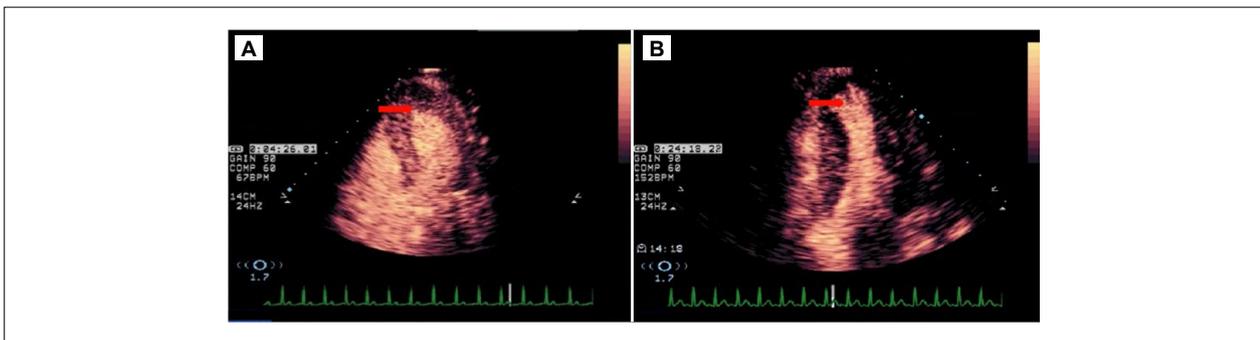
Sample contrast echocardiography under pharmacological stress with dobutamine and atropine. (A) Apical four-chamber plane at rest showing normal regional parietal motility and myocardial perfusion (red arrow). Video 5A. (B) Apical four-chamber plane at peak stress showing akinesia and a myocardial perfusion defect in the apical region (red arrow). Video 5B.
